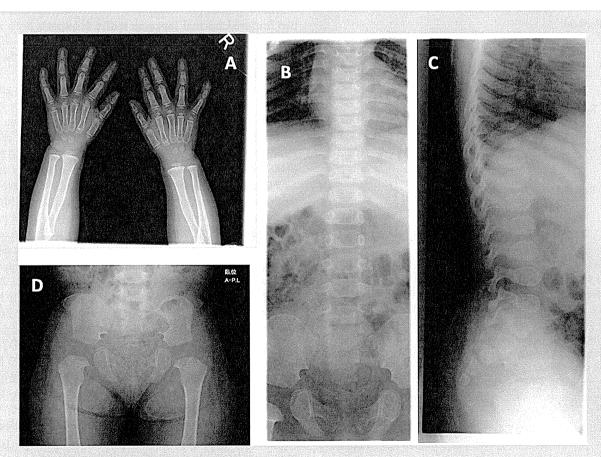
Radiographs of the patient at 3 years and 1 month of age. A: Hand A-P. Short tubular bones are minimally affected. B, C: Spine A-P and lateral. Note moderate platyspondyly, minimal scoliosis and hyperlordosis. D: Pelvis A-P. Ilia are broad and short with narrow sciatic notches. Iliac crests and acetabula are irregular. Note coxa vara and short femoral necks.
